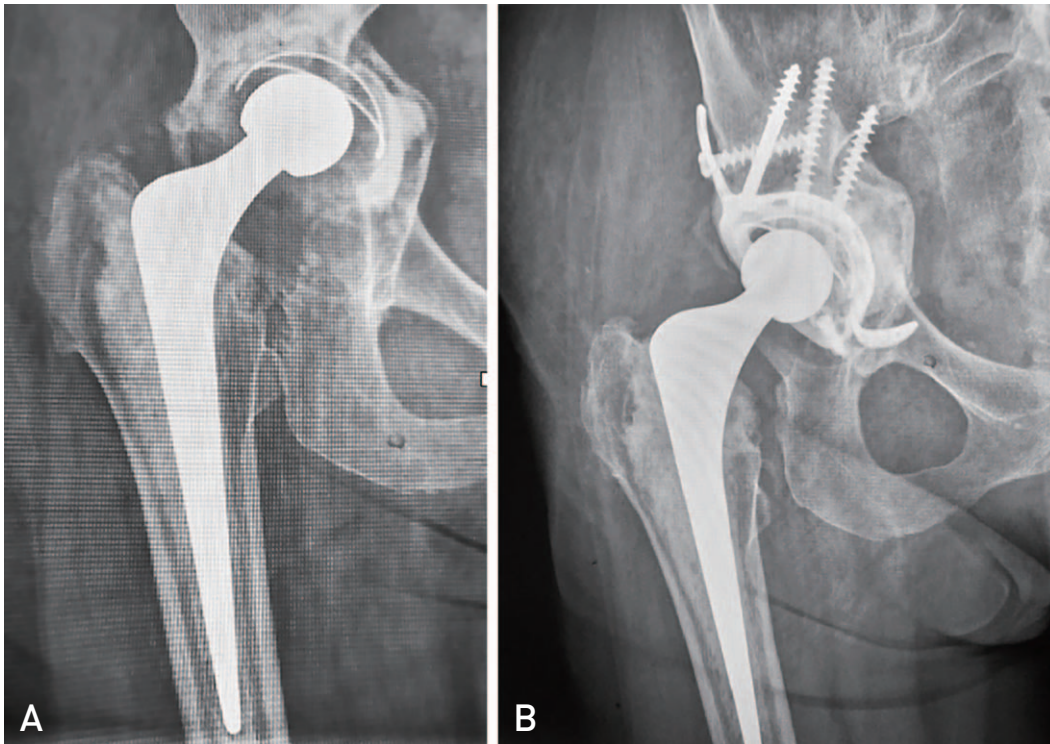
Preoperative (A) and postoperative (B) radiographs showing central and superior migration of the cemented acetabular component. The cup-cage construct is useful to stabilise and prevent proximal migration, hence affording the construct increased stability.
